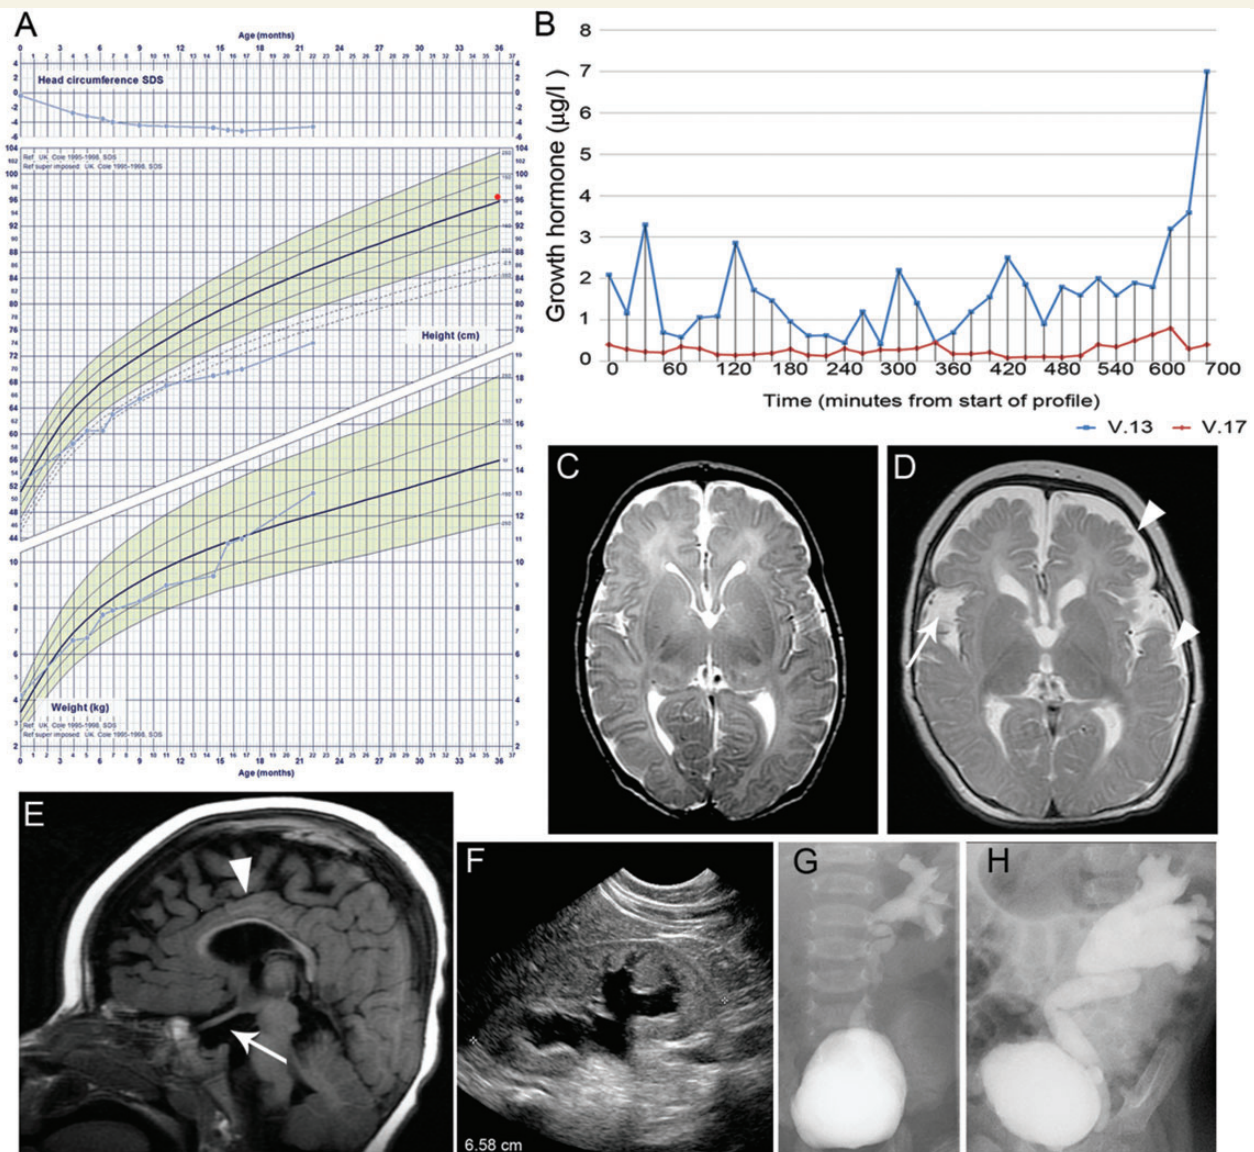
Clinical phenotype, growth hormone concentrations, kidney and urinary tract dysplasia and MRI brain abnormalities in affected patients. (A) Growth chart of Patient V:17 demonstrating initial cerebral sparing (normal initial head circumference) with subsequent progressive microcephaly indicated by head circumference <3 standard deviation scores below normal for age and sex matched controls, and the abnormal growth curve with early growth failure and increasing obesity. Mid-parental height on 50th centile is denoted by a red dot. (B) Growth hormone profiles of affected Patients V:13 and V:17 with sampling at 20 min intervals for 12 h overnight. (C and D) Sequential MRI brain of Patient V:17 performed shortly after birth (C) and at 18 months (D). Arrowhead indicates hypoplasia of the frontal and temporal lobes. Arrow indicates large Sylvian fissure. Some mature myelin (represented by the dark line on these axial T_2 -weighted images) is seen in the posterior limb of the internal capsule and is demonstrated to have progressed since birth. However, the rest of the white matter is abnormal and immature for age, both in terms of signal return (interpreted as immature myelin) as well as volume (interpreted as under-developed), demonstrating a pattern of myelination and white matter development, on the combination of T_2 and T_1 -weighted images, that is approximately equivalent to ~ 8 – 10 months of age. (E) Midline sagittal T_1 -weighted MRI brain of Patient V:17 (18 months of age), arrowhead indicates thin corpus callosum, arrow shows absent posterior pituitary bright spot and hypoplastic anterior pituitary gland. (F) Renal ultrasound of Patient V:17 at 12 months of age. Note poor corticomedullary differentiation and dilatation of collection system. (G and H) Left micturating cystourethrogram of Patient V:17 showing renal reflux on left side, which is increased at 16 months of age (G) compared with 4 weeks (F).
